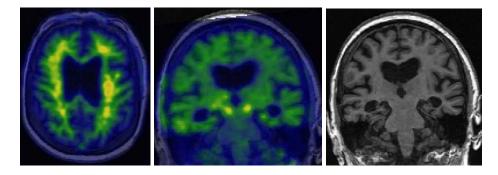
non Alzheimer's pathologic change with dementia. 86 yo, F, progressive amnestic dementia. The patient had been diagnosed clinically (i.e. without biomarkers) as "Alzheimer's disease dementia" by several physicians prior to enrolling in the Mayo Alzheimers Disease Research Center. Imaging performed for research purposes revealed a normal amyloid PET (left), normal tau PET 9 (middle) and severe medial temporal atrophy on MRI (right). The biomarker profile (A- T- N+) suggests the patient has non Alzheimer's pathologic change. Based on her biomarker profile, hippocampal sclerosis was suspected antemortem and hippocampal sclerosis with TDP43 (and without Alzheimer's disease) was later confirmed at autopsy.
